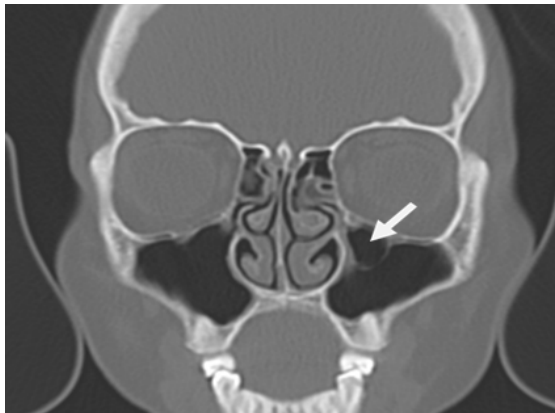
CT scan PNS coronal section showing large Haller's cell on the left side (arrow)
